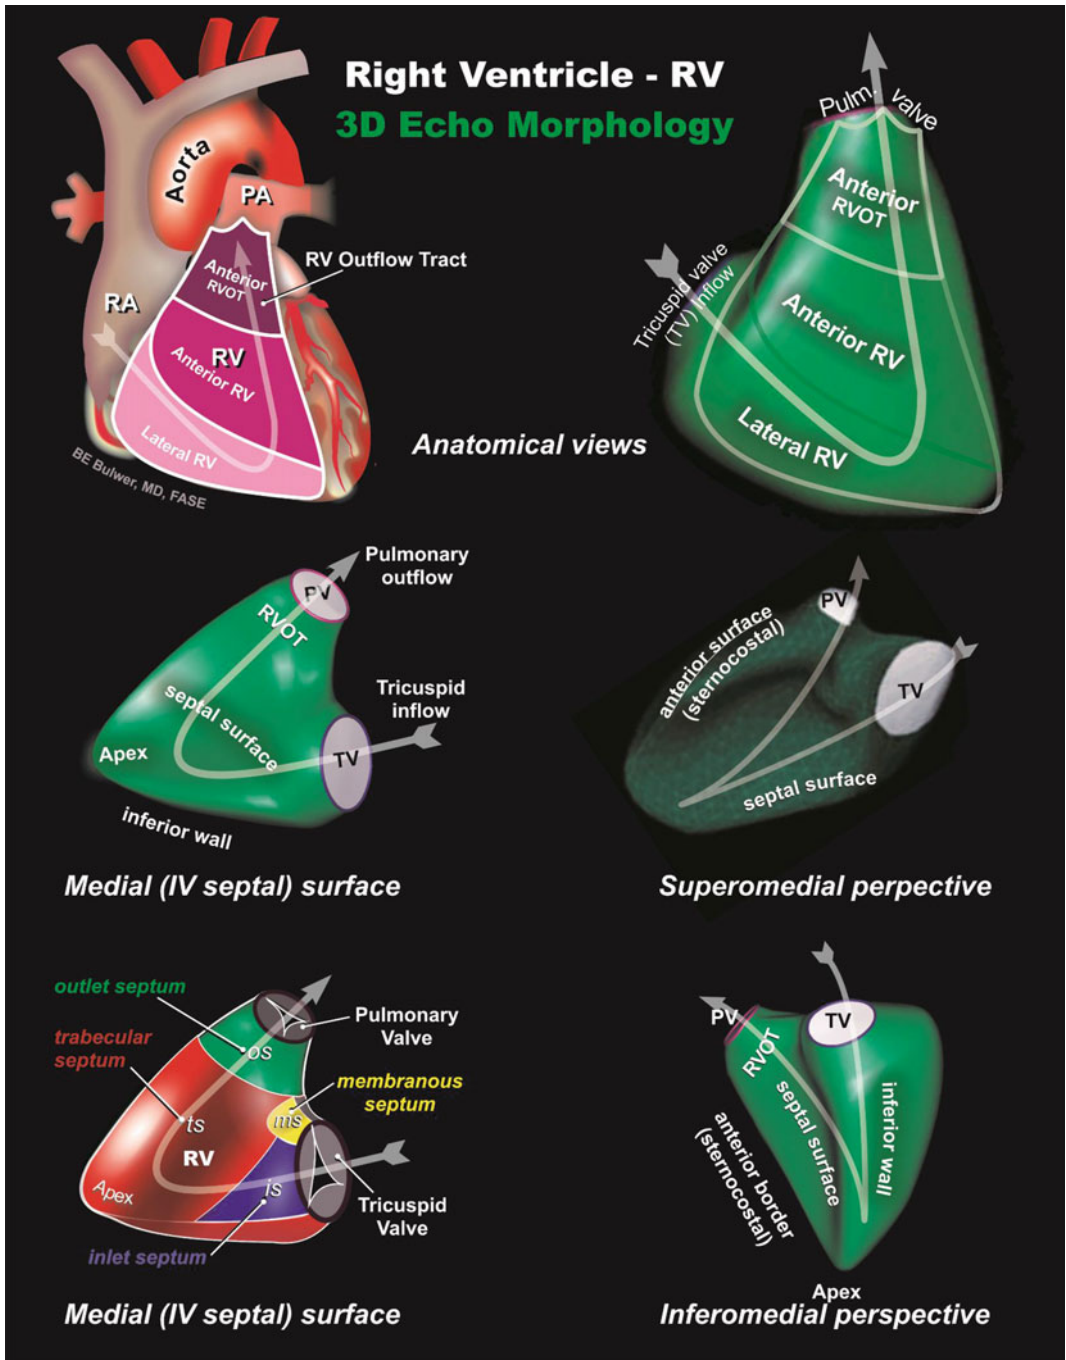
Three-dimensional (3D) echocardiographic perspectives and rendered 3D models of the right ventricle and right ventricular walls
